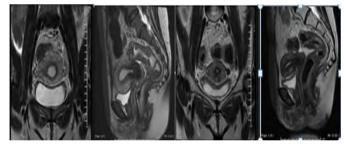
Case number 3, 48 yrs female Ca rectum MRI before treatment (coronal and axial Figure7B. Case number 3,48 yrs female Ca rectum MRI after chemo radiotherapy treatment (coronal and axial).
